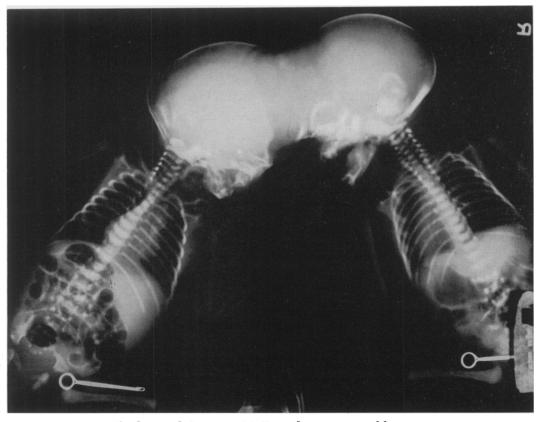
Claudette and Constance M. X-ray demonstration of bony connection.
